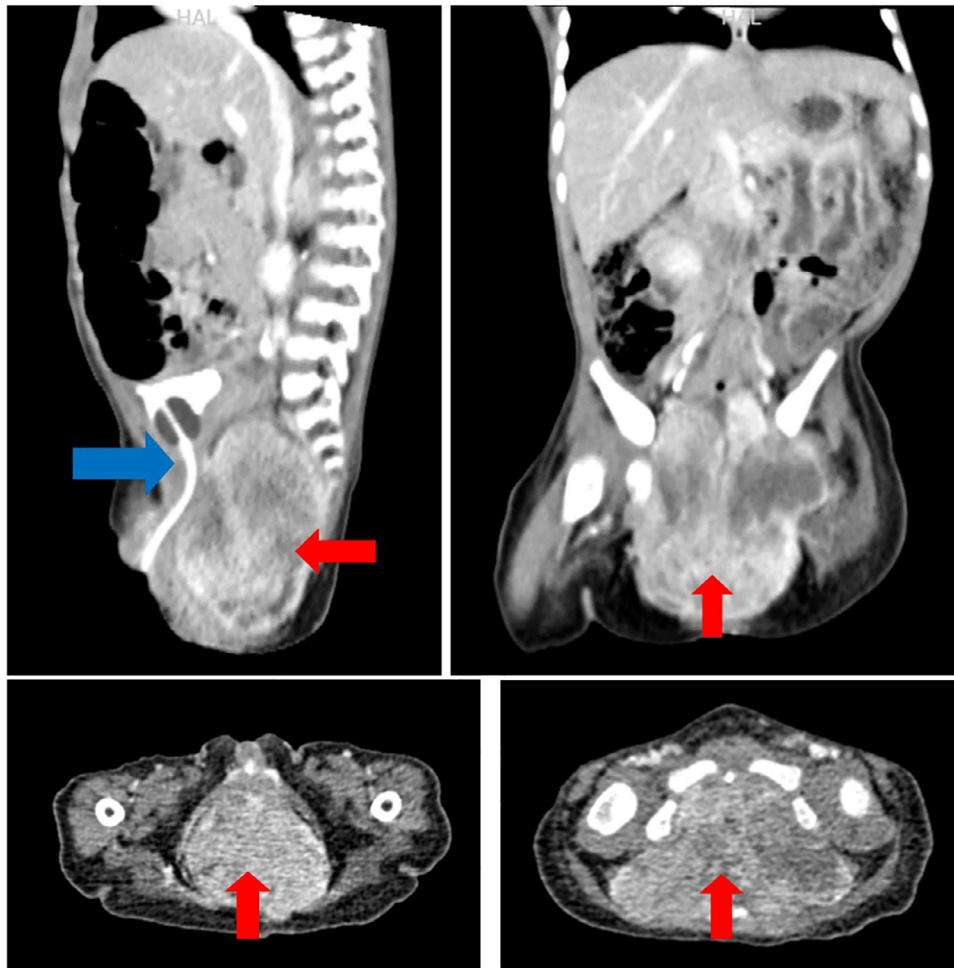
CT-scan chest-abdomen-pelvis showed a large heterogeneous enhancing mass (7.6 × 5.3 × 8.4 cm in size) (red) within the pelvis, arising from the sacrococcygeal region, pushing the urinary bladder, rectum and large bowels anteriorly (blue).
